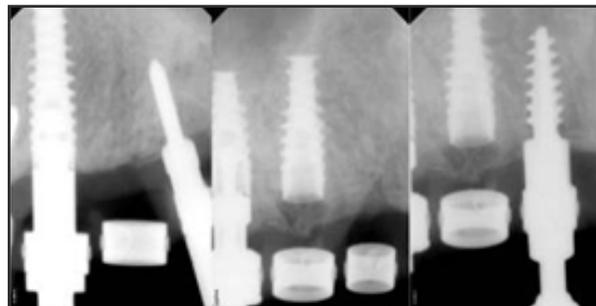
Periapical radiographs for verification of implant insertion and position
